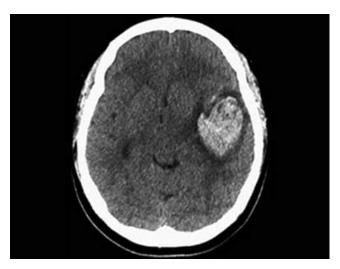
A noncontrast computed tomography axial head image demonstrates a large intraparenchymal hemorrhage in this woman with preeclampsia.
